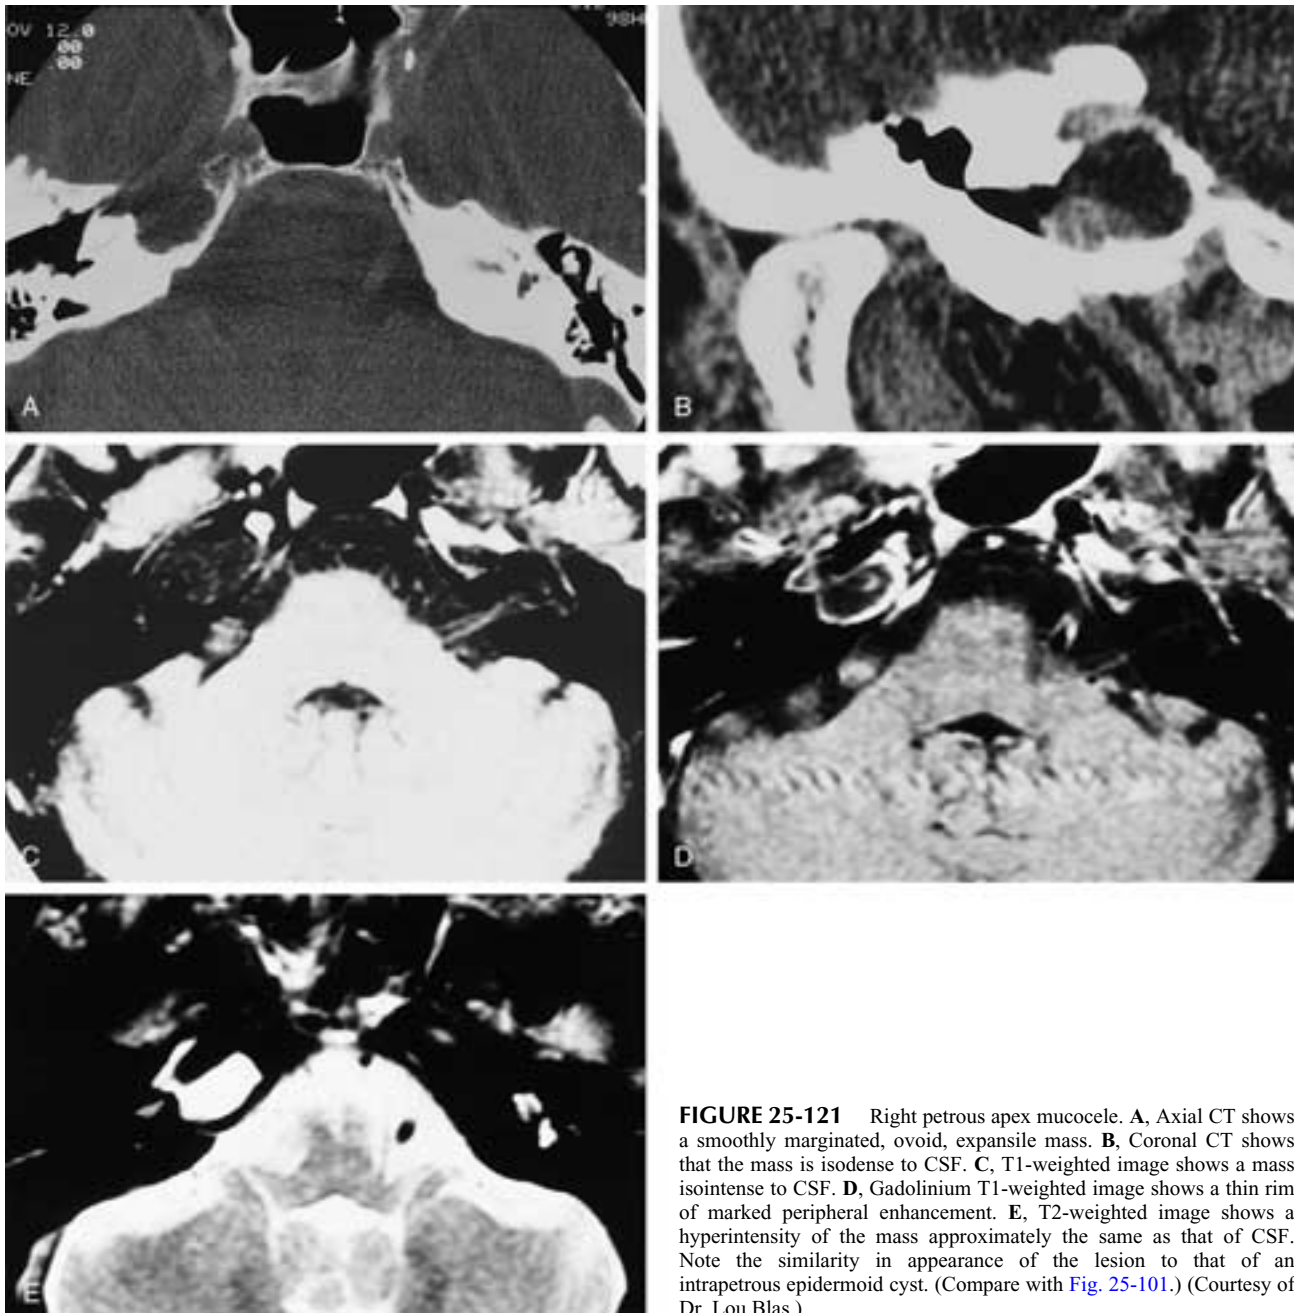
Right petrous apex mucocoele. A, Axial CT shows a smoothly margined, ovoid, expansile mass. B, Coronal CT shows that the mass is isodense to CSF. C, T1-weighted image shows a mass isointense to CSF. D, Gadolinium T1-weighted image shows a thin rim of marked peripheral enhancement. E, T2-weighted image shows a hyperintensity of the mass approximately the same as that of CSF. Note the similarity in appearance of the lesion to that of an intrapetrous epidermoid cyst. (Compare with Fig. 25-101.) (Courtesy of Dr. Lou Blas.)
